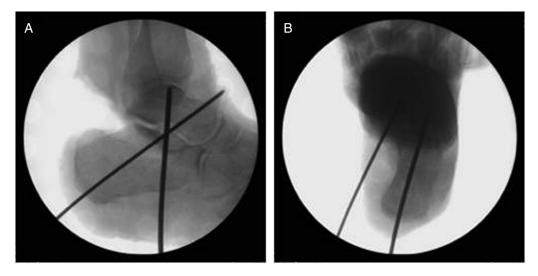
(A) Harris heel and (B) lateral foot fluoroscopic radiographs demonstrating guidewire placement before reaming.
